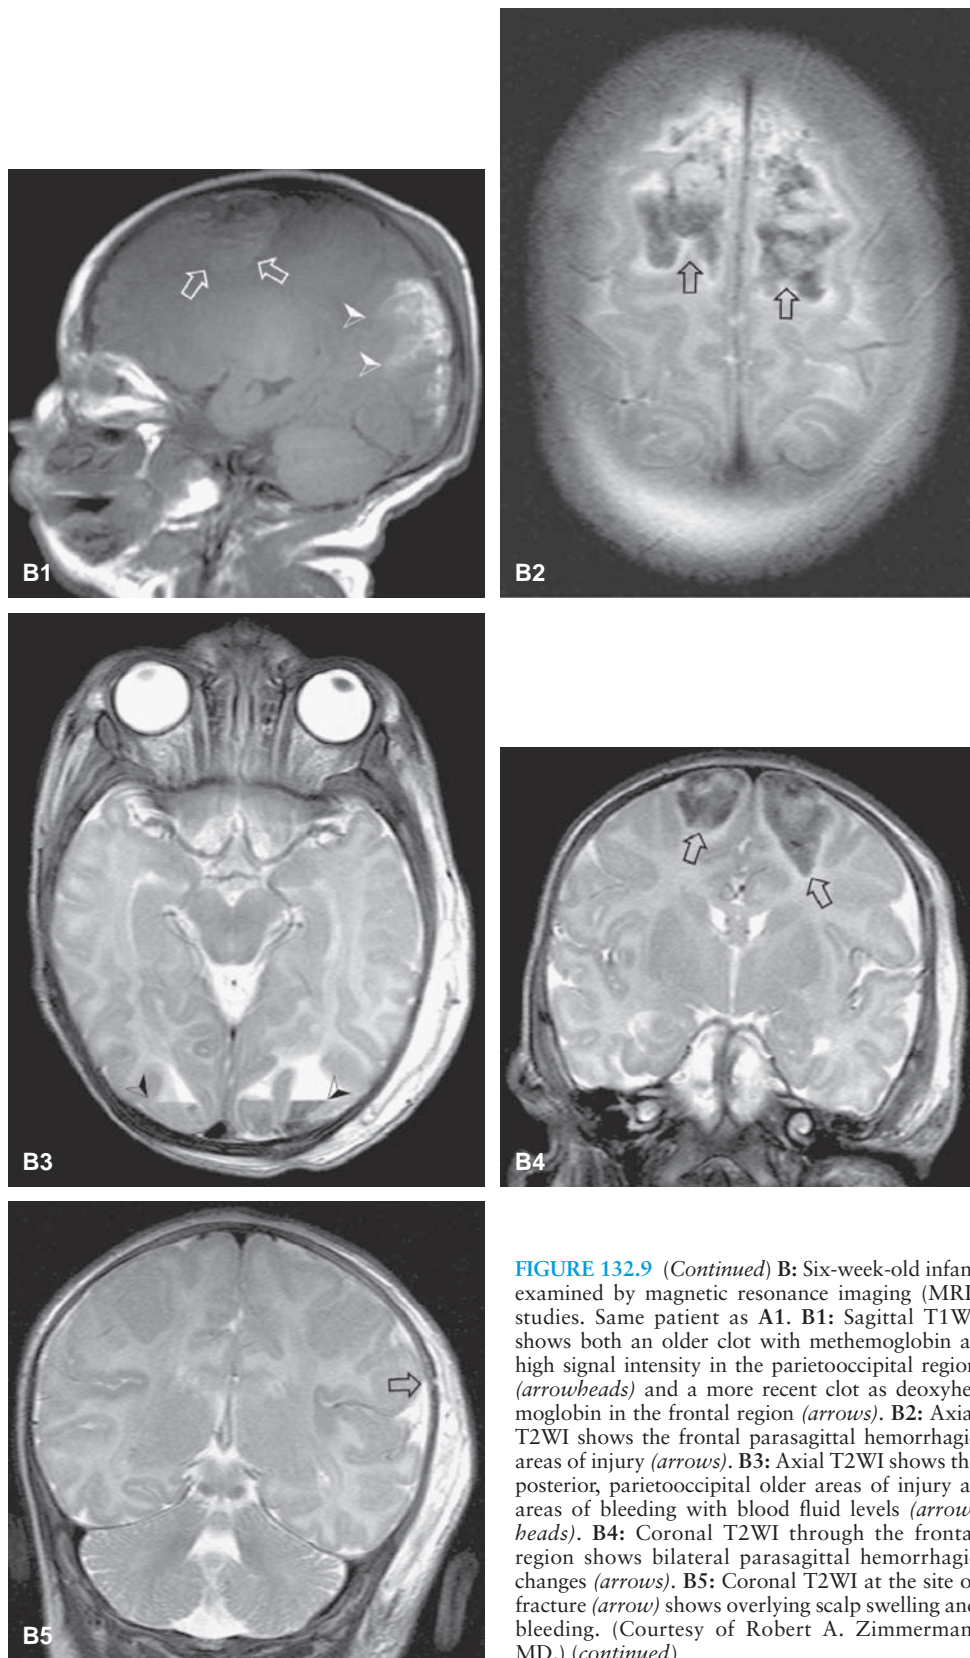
(Continued) B: Six-week-old infant examined by magnetic resonance imaging (MRI) studies. Same patient as A1. B1: Sagittal T1WI shows both an older clot with methemoglobin as high signal intensity in the parietooccipital region (*arrowheads*) and a more recent clot as deoxyhemoglobin in the frontal region (*arrows*). B2: Axial T2WI shows the frontal parasagittal hemorrhagic areas of injury (*arrows*). B3: Axial T2WI shows the posterior, parietooccipital older areas of injury as areas of bleeding with blood fluid levels (*arrowheads*). B4: Coronal T2WI through the frontal region shows bilateral parasagittal hemorrhagic changes (*arrows*). B5: Coronal T2WI at the site of fracture (*arrow*) shows overlying scalp swelling and bleeding. (Courtesy of Robert A. Zimmerman, MD.) (continued)
